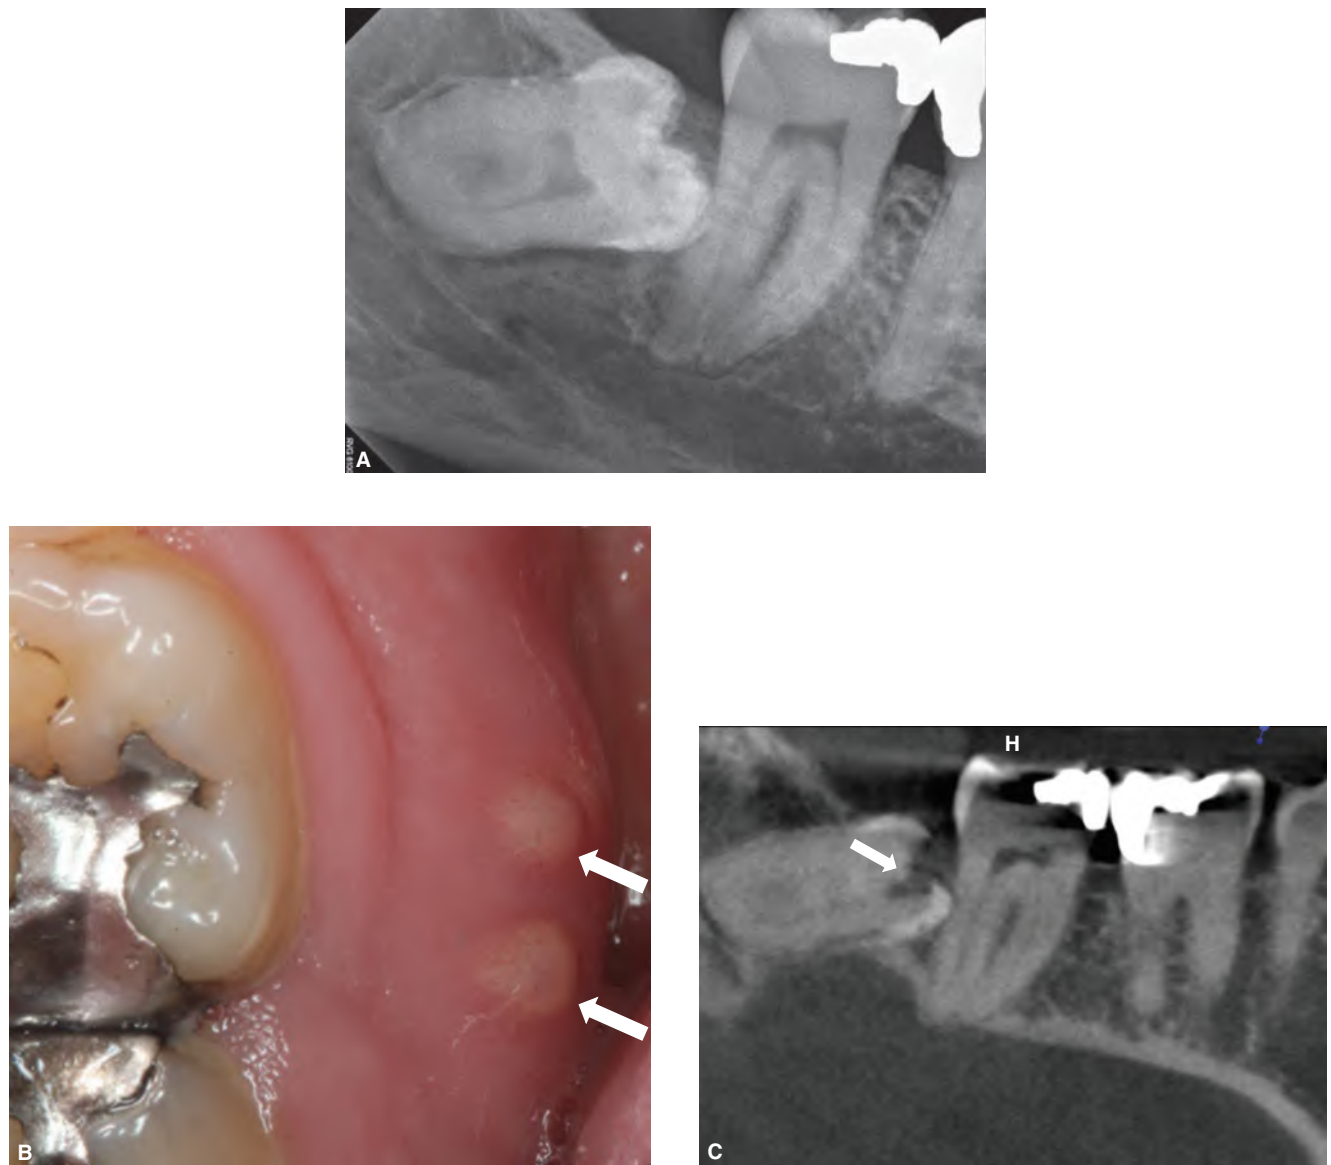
8 Planar imaging is limited by superimposition of anatomic features. A. Initial periapical image of the mandibular right second molar and bony impacted-third molar shows no pathologic findings. B. A photograph of two nonproductive sinus tracts on the lingual of the mandibular right second molar that suggest a lesion in the supporting bone (solid arrows). C. CBCT of the same region shows a wedge-shaped resorptive lesion in the crown of the third molar (solid arrow) with erosion of the lingual aspect of the alveolar crest on the distal and mesial aspects of the mandibular second molar; features consistent with external resorption.
